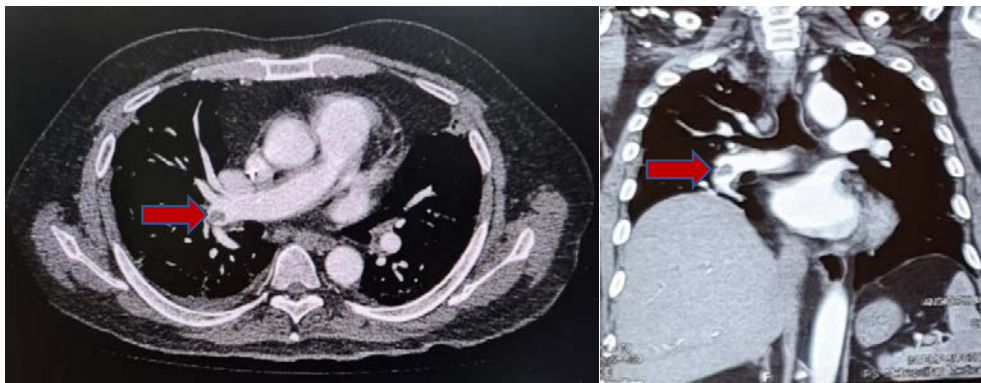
(A) and (B) CT-pulmonary angiography showed intra-luminary hypodense lesion in posterior and basal segment of right pulmonary artery suggesting pulmonary embolism.
